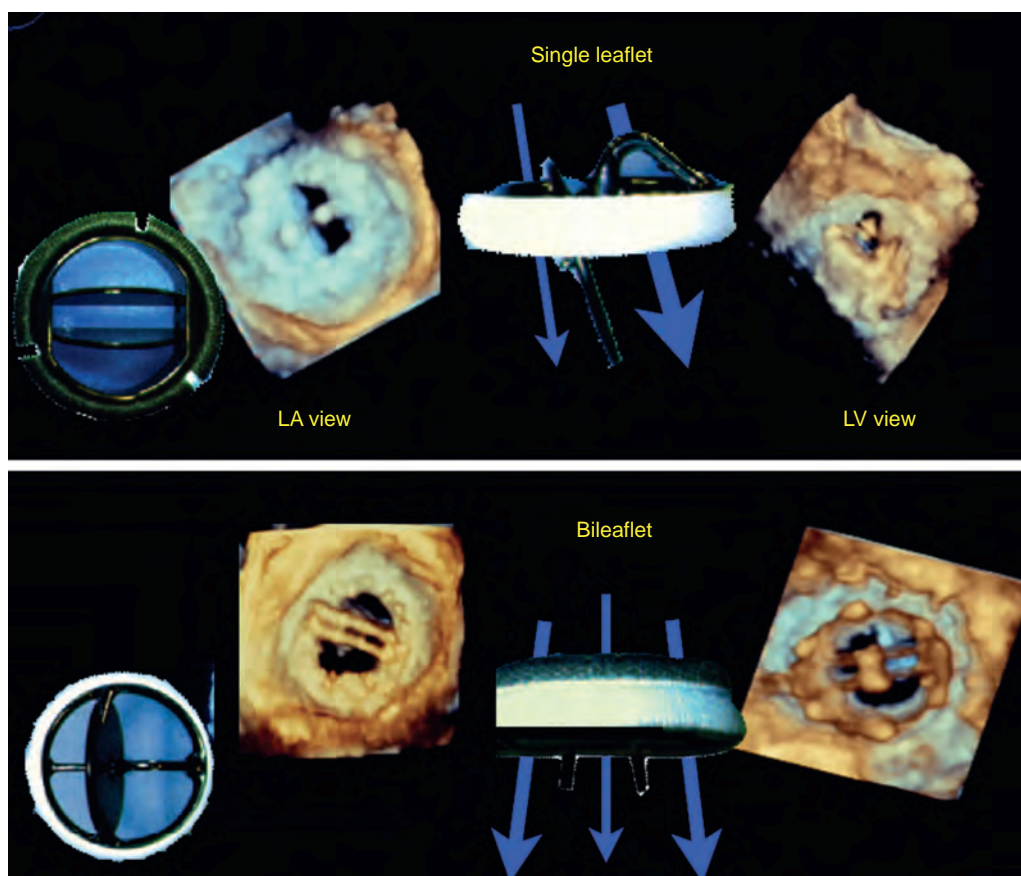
Flows across mechanical prosthetic valves. This figure highlights the differences in both appearance and flow across a single-leaflet and a bileaflet mechanical prosthetic valve. Three-dimensional echocardiographic imaging shows valves, in mitral position, from the perspectives of the left atrium (LA) and left ventricle (LV) and highlights the paths through which blood flows while traversing the valve.
